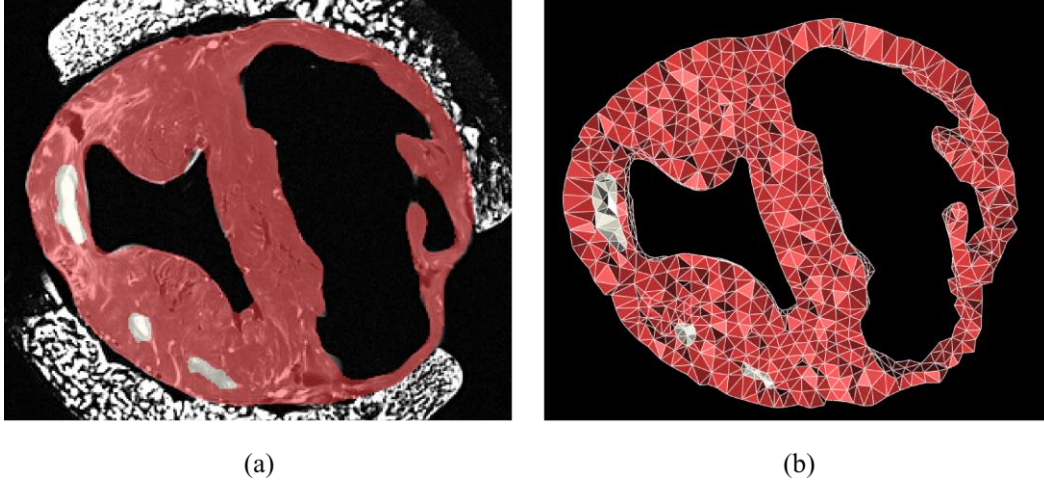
(a) Image segmentation revealing healthy tissue (pinkish red) and gel injectates (white) overlaid on a MRI short axis slice. (b) Corresponding FE mesh for the same short axis region.
